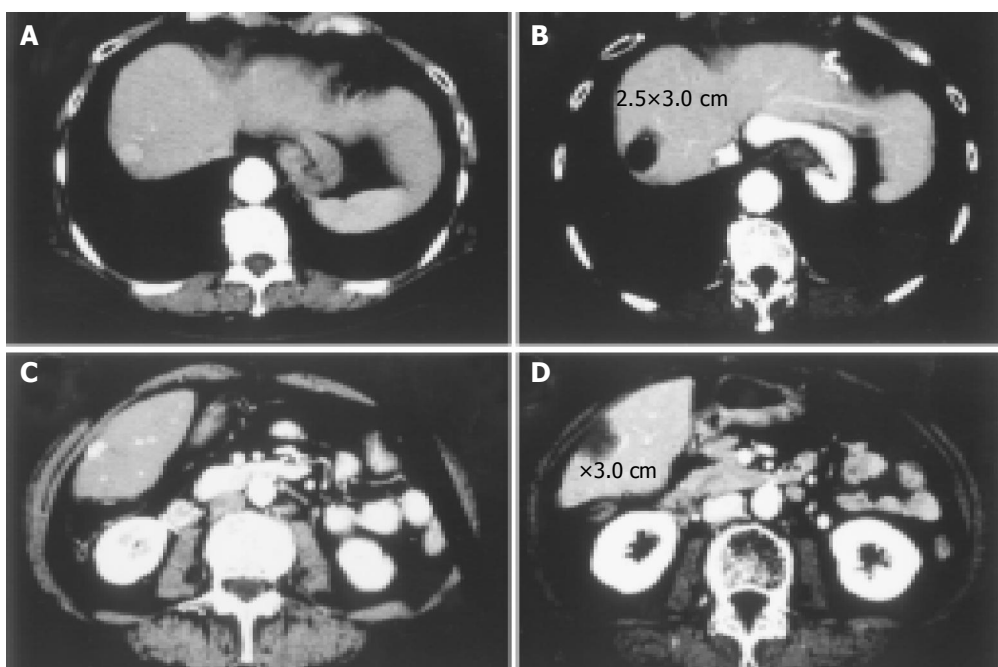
Two cases with small-sized HCCs treated with PEI-RFA under low power output control are shown. Contrast-enhanced CT before (A, C) and after (B, D) PEI-RFA. Small HCCs of 1.5 cm in the longest diameter were located in the S8 region of the liver in both cases. In both cases, RFA was performed at 40 W for 5 min. Though the ablation was performed at relatively low power output for short duration, the coagulated necrosis larger than 2.5 cm was induced after the treatment.
